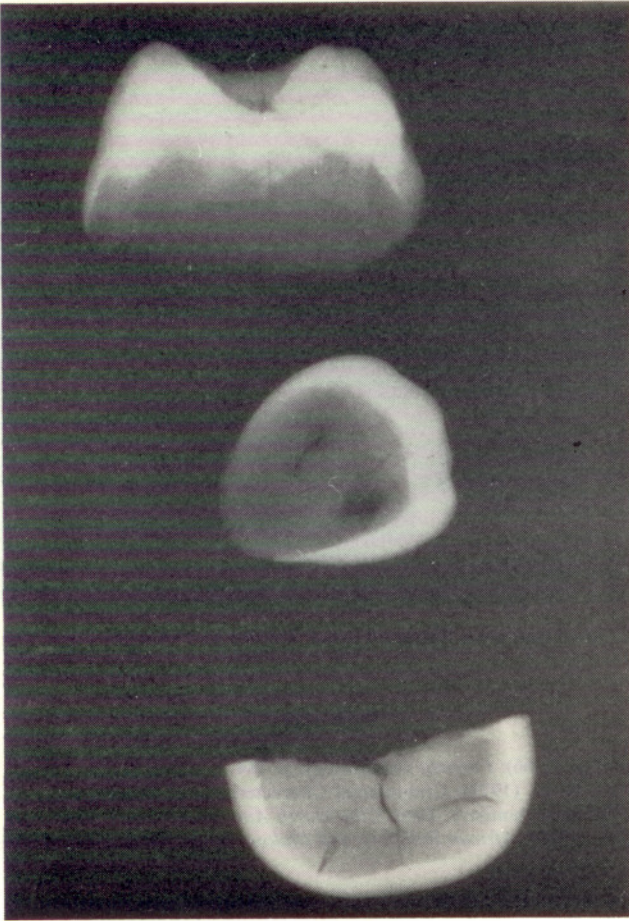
Radiograph of enamel shells.
